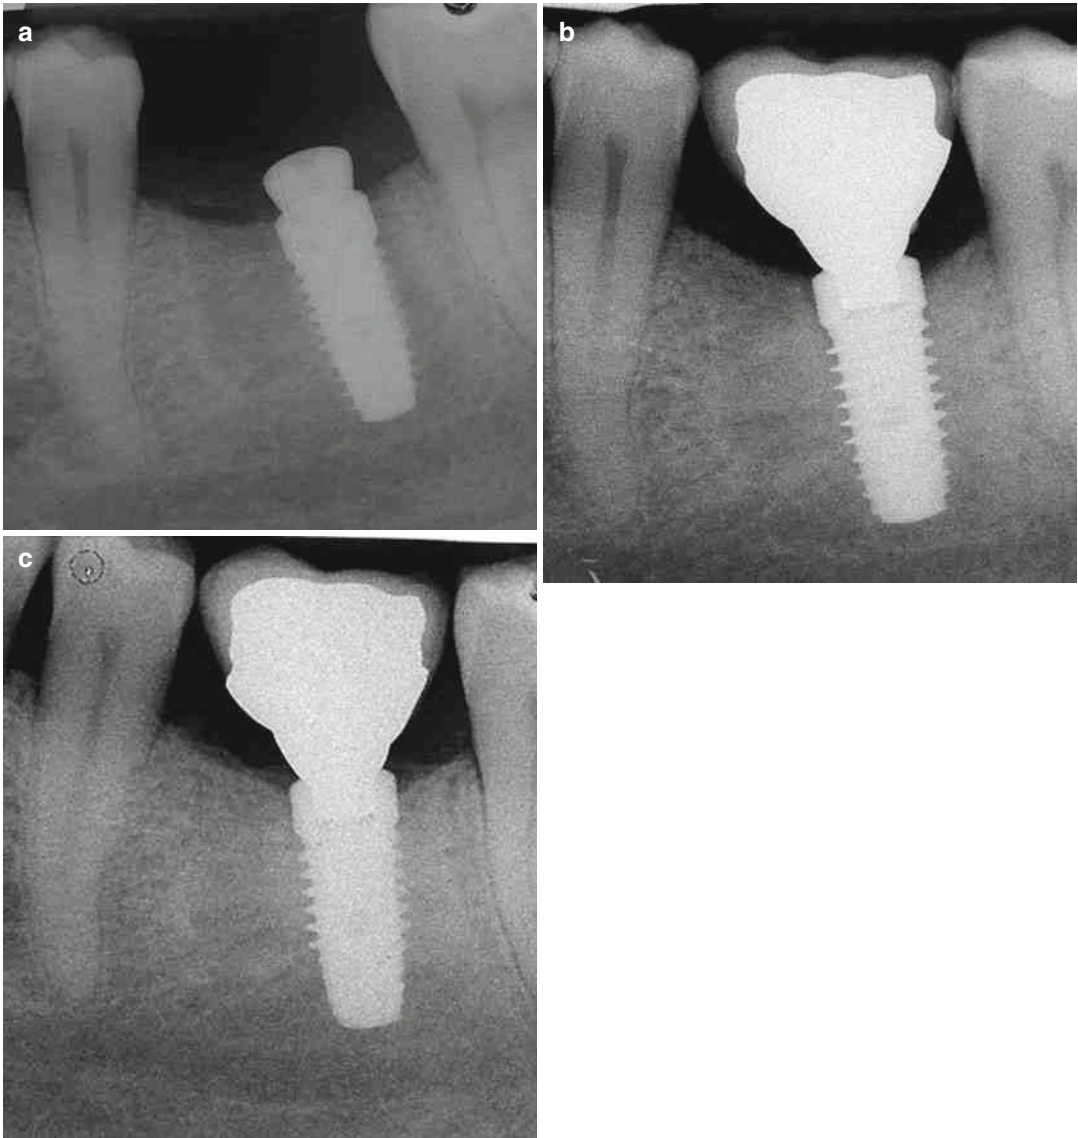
Radiographic appearance of a platform-switched implant (Reproduced with permission from Del Fabbro and coll.)
